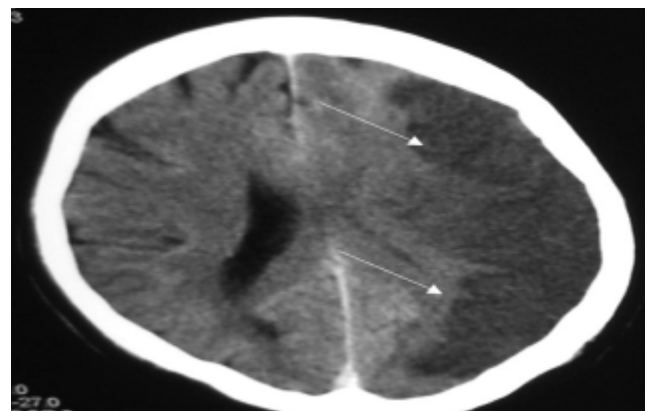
Axial section Non-Contrast Computed tomography of brain showing large area of acute ischemic infarct involving left frontal and parietal lobes along left middle cerebral artery territory.
